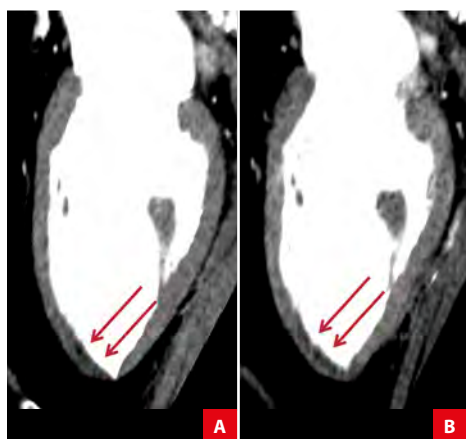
Rest and stress myocardial CT perfusion. Long-axis slices in rest (A) and stress (B) show an apical defect (arrows).
